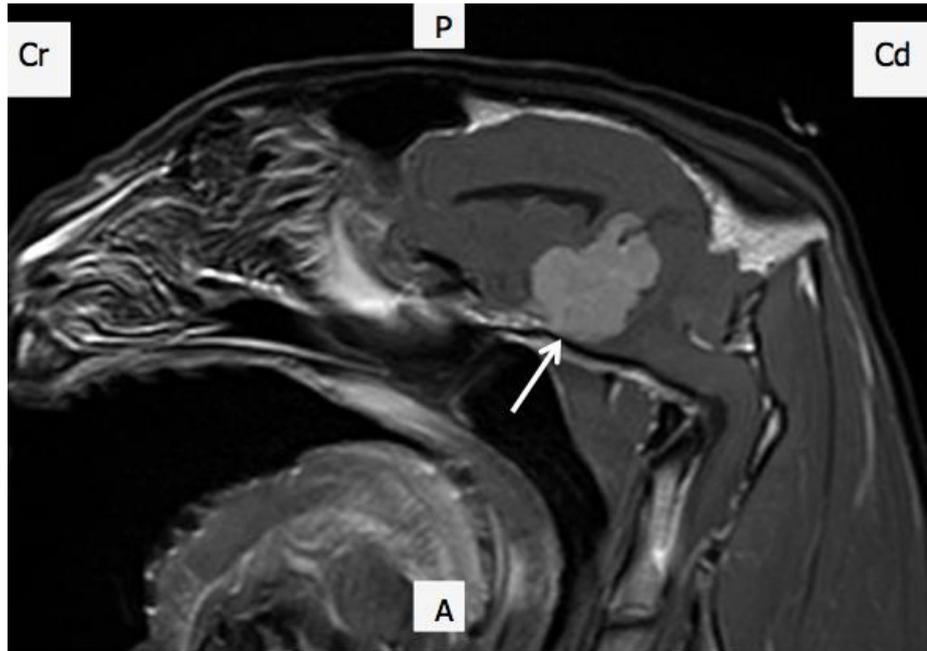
Sagittal contrast MRI of a 7-yr-old female leopard (*Panthera pardus fusca*) showing mass effect on the pons with involvement of petrous bone at the petroclival region due to a space-occupying cerebello-pontine angle lesion (white arrow). Orientation of sagittal images is denoted by A= anterior, P= posterior, Cr= cranial and Cd= caudal
